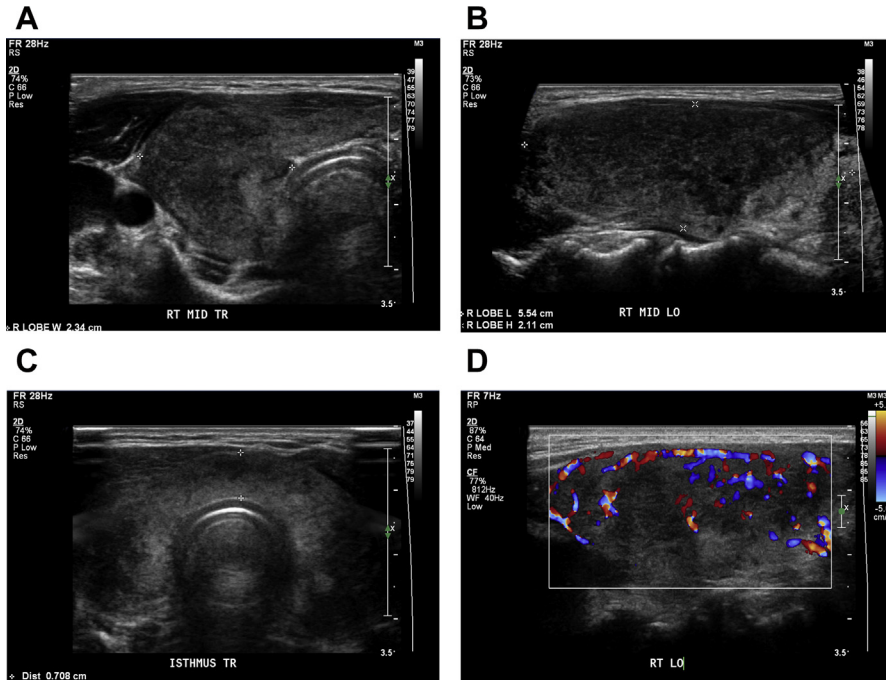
A 51-year-old woman with subacute thyroiditis, likely post viral. (A–C) Gray-scale images in transverse (A, C) and longitudinal (B) planes show diffuse small hypoechoic areas throughout an enlarged thyroid, with focal areas of overall decreased echogenicity, so-called “lava flow” pattern. (D) In the acute phase, increased color Doppler flow is present in the right lobe between the hypoechoic areas. Cursors on (A, B) represent thyroid lobe measurements in the transverse and longitudinal planes; cursors on (C) show the measurement of isthmus thickness, which is enlarged at greater than 3 mm.
